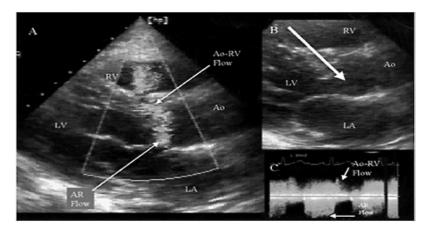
Knife stabbing injury. The entry wound through the right ventricle was closed urgently in the emergency room. A continuous machinery murmur was noted. Panel A shows jets of blood from a rta (Ao) to right ventricle (RV), and of aortic regurgitation (AR). Panel B demonstrates clearly the knife track (white arrow) through the base of the ventricular septum, through the right coronary cusp of the aortic valve, and into the aortic root (Ao). Panel C demonstrates continuous Ao-RV continuous-wave Doppler flow above the baseline and diastolic aortic regurgitation flow below the baseline.
